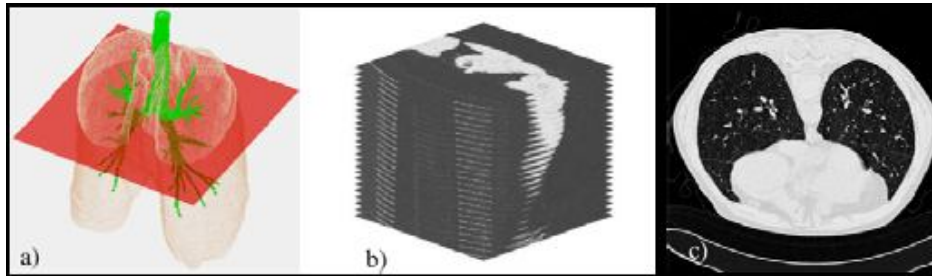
(a) Human lung (b) Continuous HRCT images (c) Normal HRCT slice [6]
